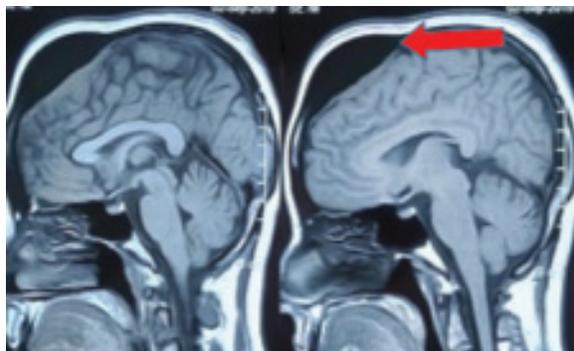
Magnetic resonance imaging T1W pre-contrast sagittal images showing expansile hypointense lesion in diploic space of fronto-parietal bone
